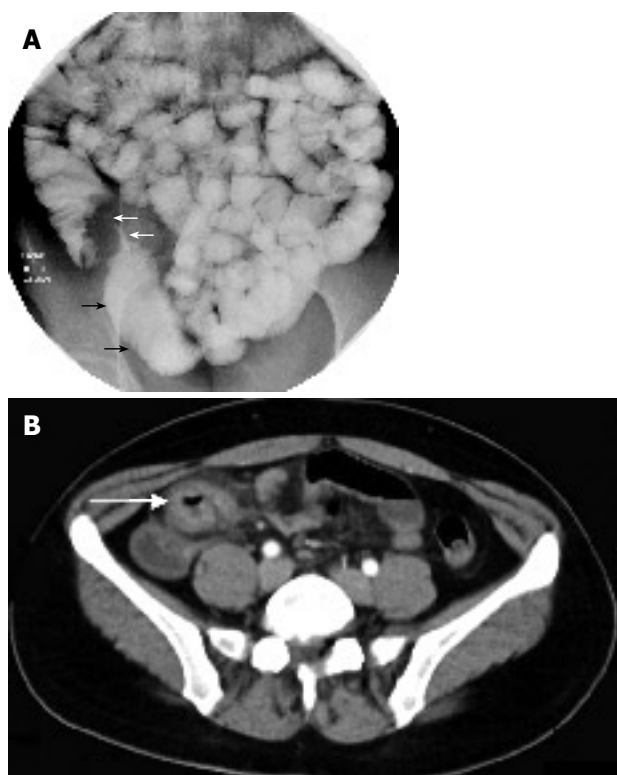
Barium follow through showing a stricture at the terminal ileum (white arrows) typical of Crohn's disease with dilated ileum just proximal to it (black arrows) (A) and axial CT image showing the thickened terminal ileum (arrow) and associated inflammatory change (B).
